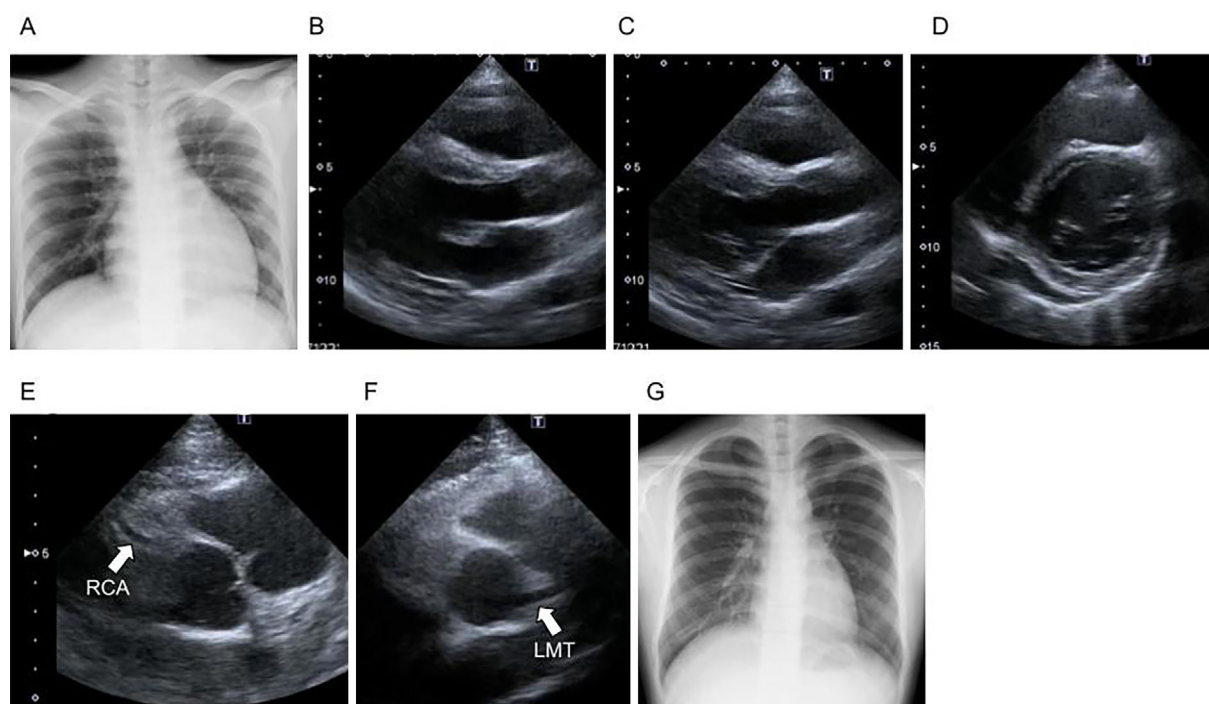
Imaging findings of the case 2 at admission. A: Chest X-ray at admission. B: TTE: diastolic view of left ventricle, parasternal long axis view. C: TTE: systolic view of left ventricle, parasternal long axis view. D: TTE: pericardial effusion, parasternal short axis view. E: TTE: RCA. F: TTE: LMT. G: Chest X-ray at discharge.
